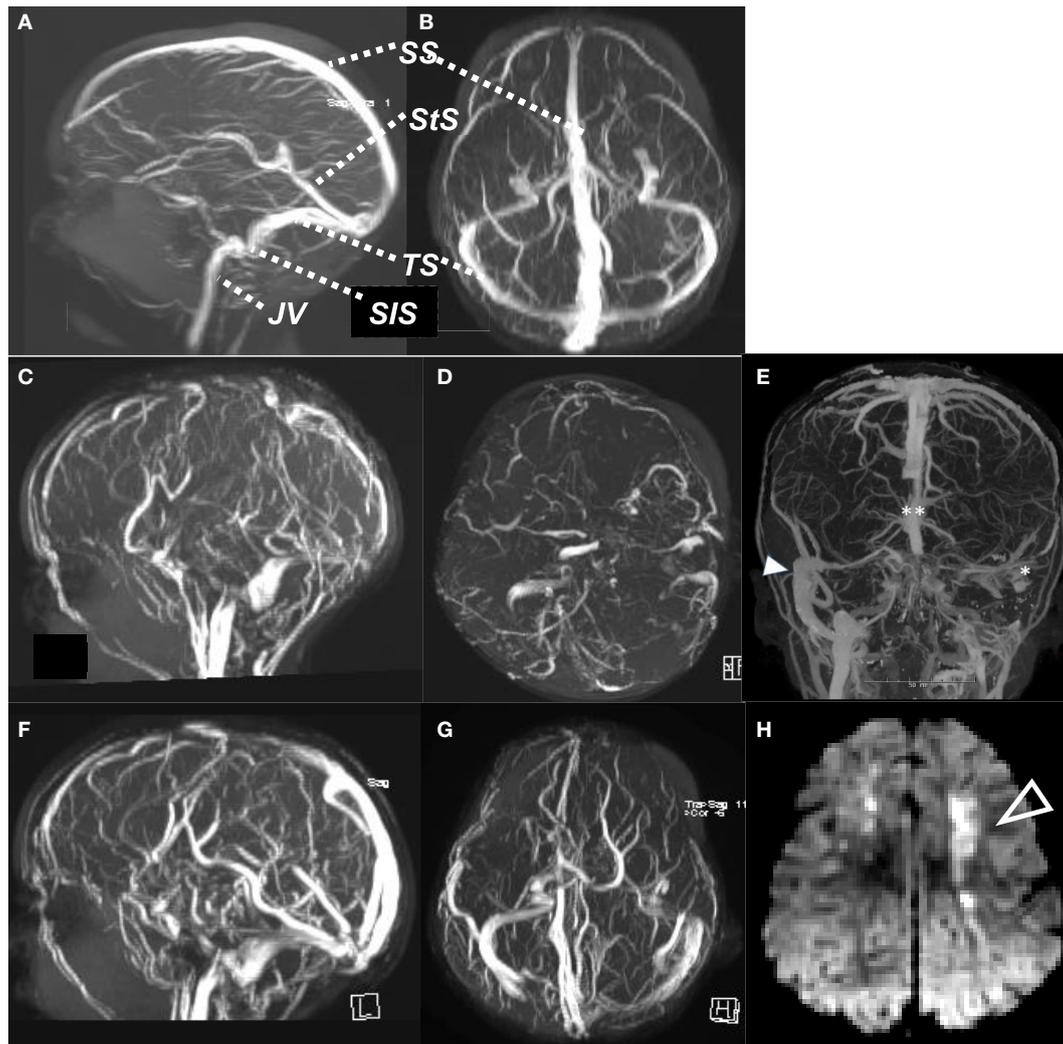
Normal MR venogram, sagittal view (A), axial view (B). Case of cerebral sinovenous thrombosis, acute MR venogram sagittal (C) and axial (D), showing absent flow signal in SS, both TS and StS, with ischemic change (arrow) in cortical white matter on DWI (H). Computed tomography venogram (E) of child with mastoiditis and occlusive thrombus of left SiS and TS (*) and distal SS (), compared to patent right SiS and TS (arrow). MR venogram 6 months later (F,G), with recanalization of SS, StS, and TS. SS, sagittal sinus; StS, straight sinus; TS, transverse sinus; SiS, sigmoid sinus; JV, jugular vein.
